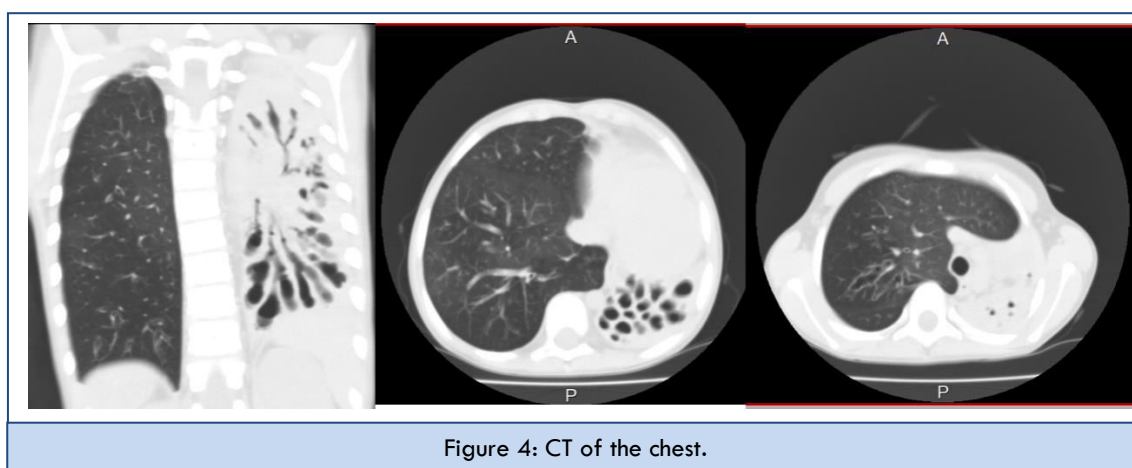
CT of the chest.
